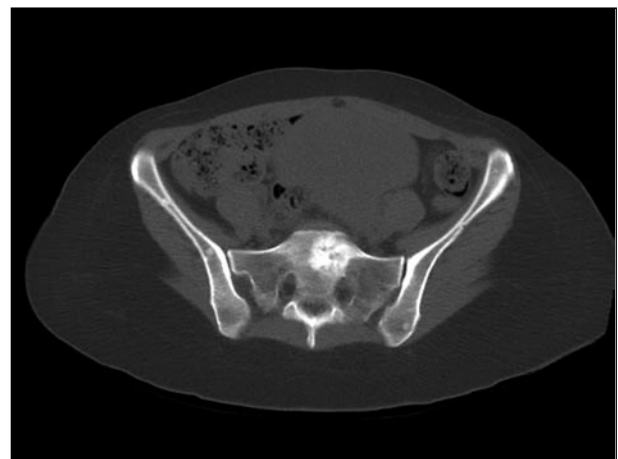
CT scan of pelvis showing sclerotic lesions in sacrum and ilium
